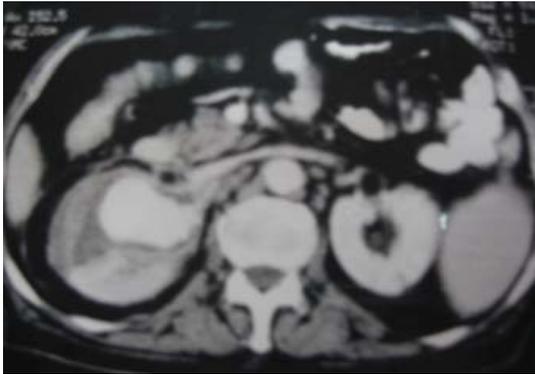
CT scan shows intrarenal aneurysm of the right renal artery.
